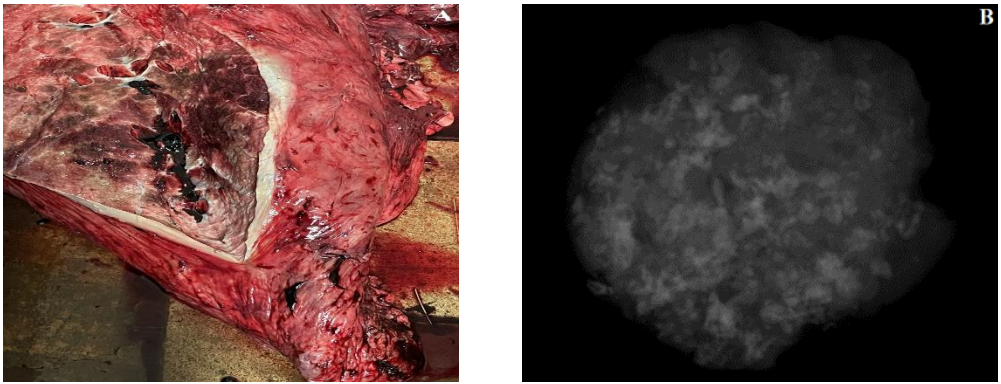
Pneumonic lung of an Indian elephant. A. Smooth and moist cut surface from which oozes cloudy and liquid exudate. B. X-ray examination of a bony lesion in the lung structure with varying intensity of calcification.
